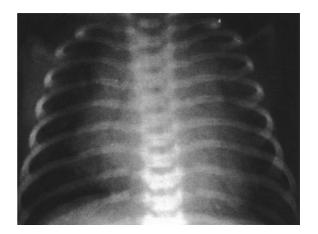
Mitral valve disease: radiography. Anteroposterior view in an infant with severe mitral valve stenosis, showing left atrial dilatation, straightening of the left cardiac border, elevation of the left bronchus, prominent upper pulmonary veins, increased interstitial markings, Kerley lines, pulmonary artery trunk and branches dilatation, right ventricular dilatation
